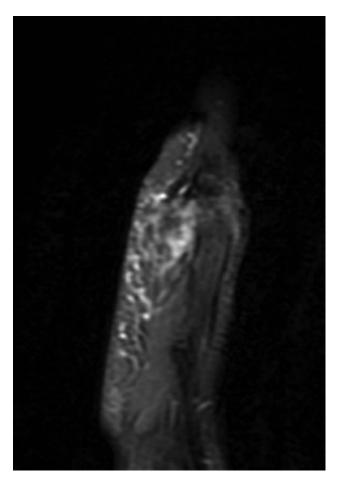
Contrast T2-weighted MRI sagittal view of the left-hand ill-defined heterogeneous soft-tissue mass.
